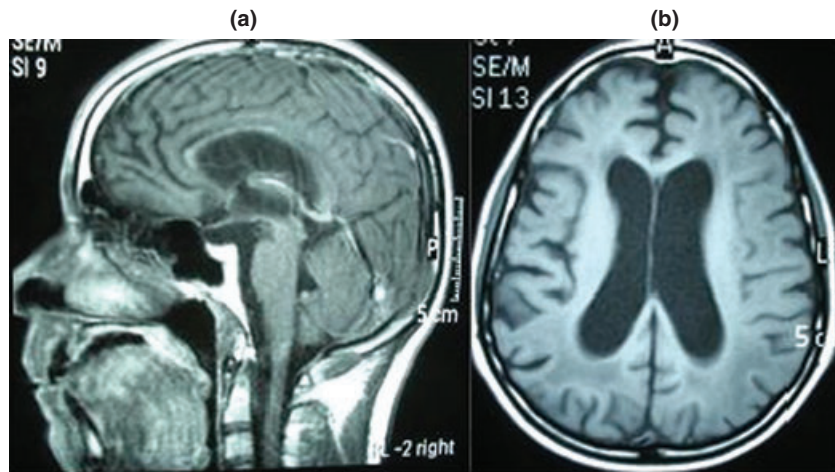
Sagittal (a) and axial (b) T2 magnetic resonance imaging of a patient with chronic (normal pressure) hydrocephalus. Note the corpus callosum atrophy, lateral ventricles enlargement as well as cortical and white matter atrophy. Likewise, it is possible to observe transependymal flow and rounded horns.
